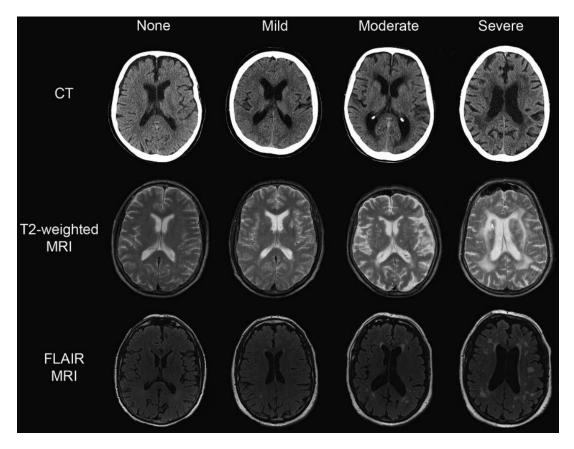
Stages of leukoaraiosis severity showed in CT scan and T2-weighted MRI (Grueter & Schulz, 2012)
